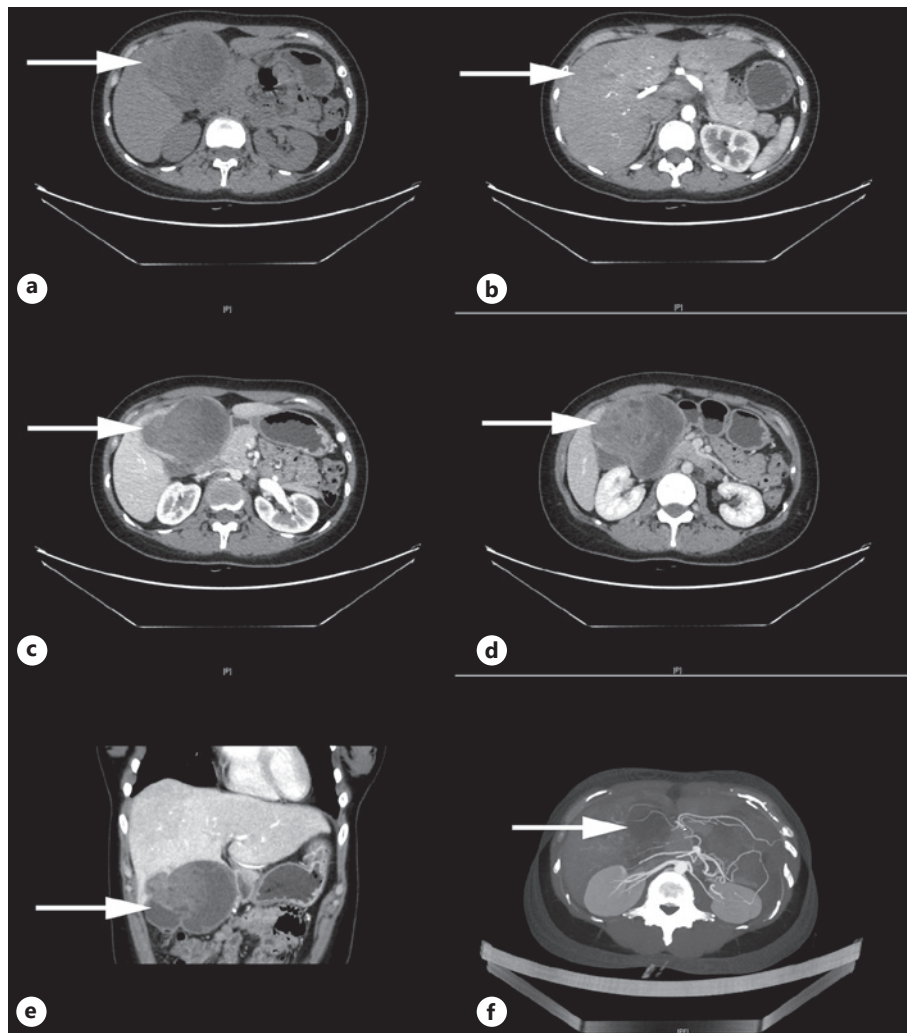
CT imaging of BAF. CT imaging features of BAF in the liver of a 30-year-old female patient. a Medium. b Arterial phase. c Venous phase. d Portal phase. e Coronal plane image. f Processed image. The CT scan showed a low-density mass (98 mm × 81 mm × 71 mm) between the left inner lobe of the liver and the descending segment of the duodenum. The mass was uneven with cystic portion and solid parenchyma. The lesion and the left inner lobe of the liver were not clearly demarcated, and the adjacent gallbladder, duodenum, and pancreas were significantly compressed (e). The mass showed strip-like enhancement in the arterial phase and low enhancement in venous and delayed phase (b–d). The upper abdominal CTA showed that the blood supply came from the left inter-hepatic artery and its branches, and the right renal artery and vein was compressed (b, f).
